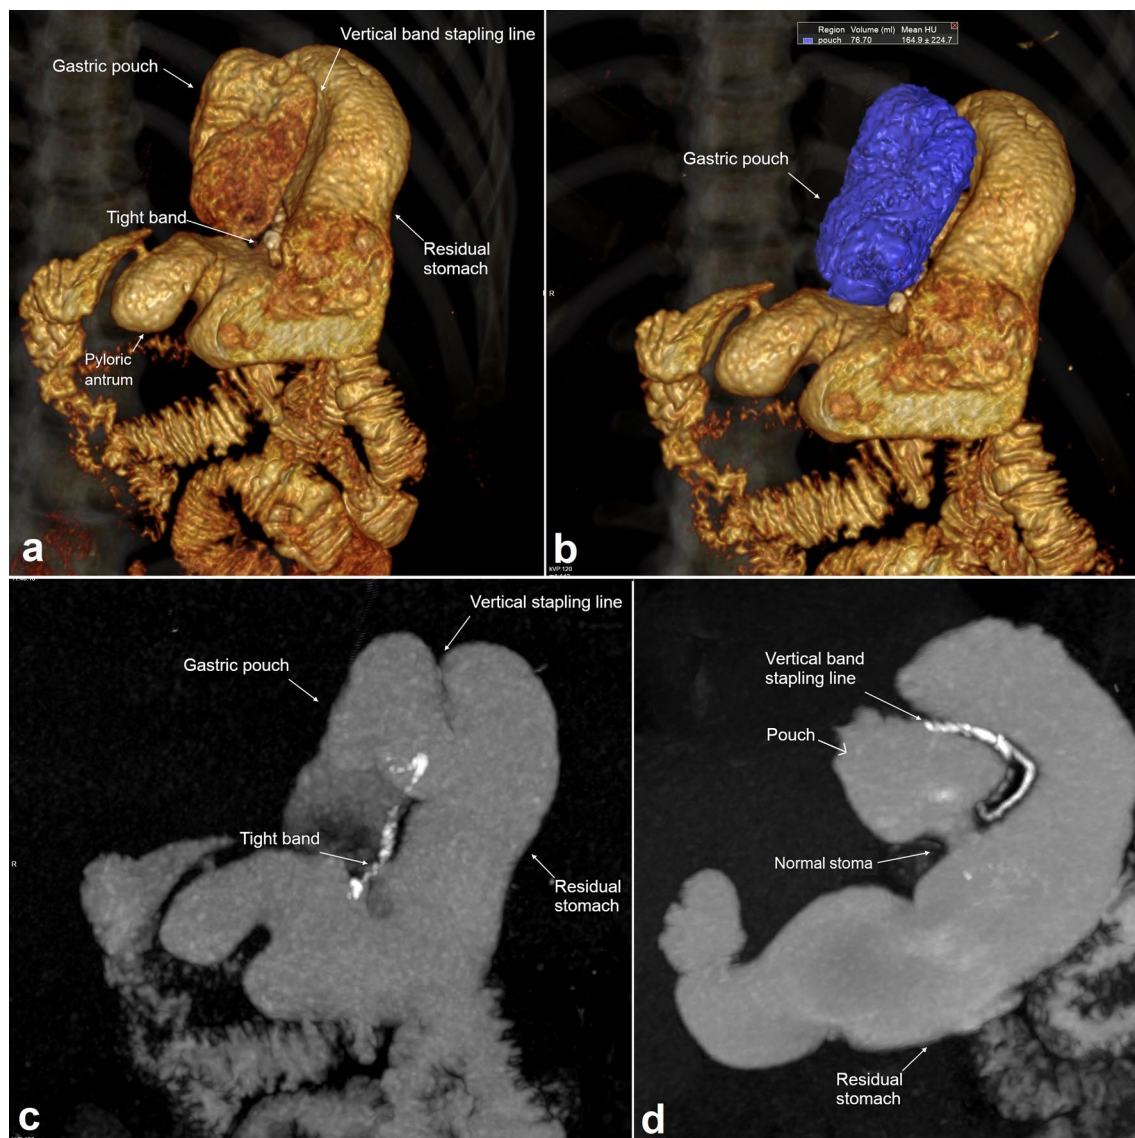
Gastric pouch dilatation after butterfly gastroplasty with recurrent weight gain. CT gastric volumetry image (a) clearly delineate gastric pouch (blue color) with its volume measuring 76 ml. 3D volume rendered image (b) and MIP reconstruction (c) demonstrates the anatomical changes including intact stapling line and widely patent connecting channel (stoma)Fig. 3 Hiatus hernia complicating butterfly gastroplasty with symptomatic GERD. Semitransparent 3D volume rendered image (a) accurately depicts the anatomical changes including intact stapling line with sizeable hiatal hernia containing the whole gastric pouch. The herniated gastric pouch is dilated as well, its volume = 107 ml (b). Coronal reformatted image (c) clearly demonstrates the herniated gastric pouch into posterior mediastinum well extending above diaphragm through widened esophageal hiatus
